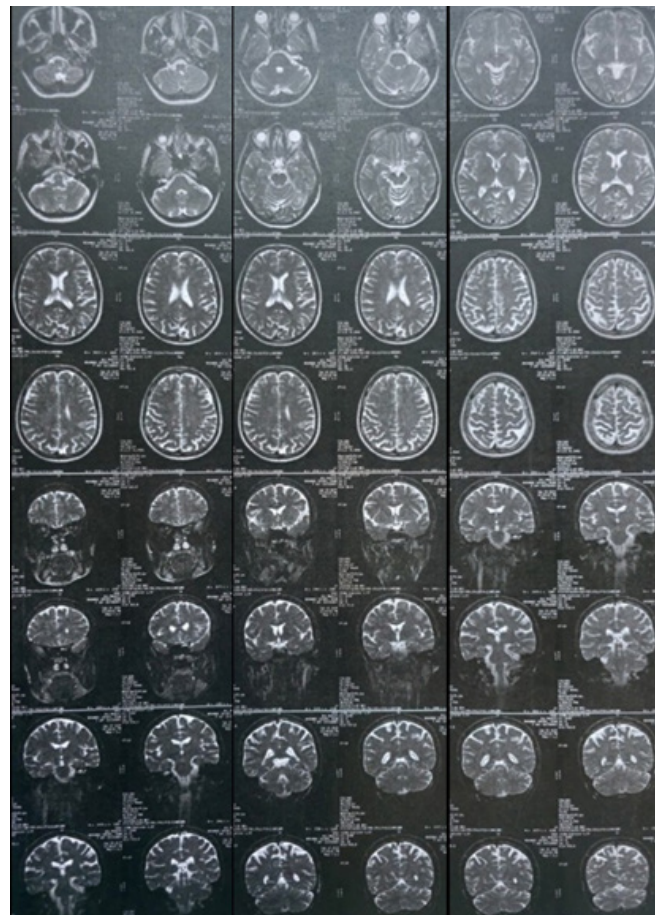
Before exosome, Brain MRI with contrast was done. Technique was axial T1, T2, PD/W and sagittal T2/W and coronal T1W images. Findings are as follows: Evidence of multiple focal abnormal Signal intensity areas in periventricular & pericallosal white matter is seen, which are mostly suggestive of demyelinating plaques of multiple sclerosis.
